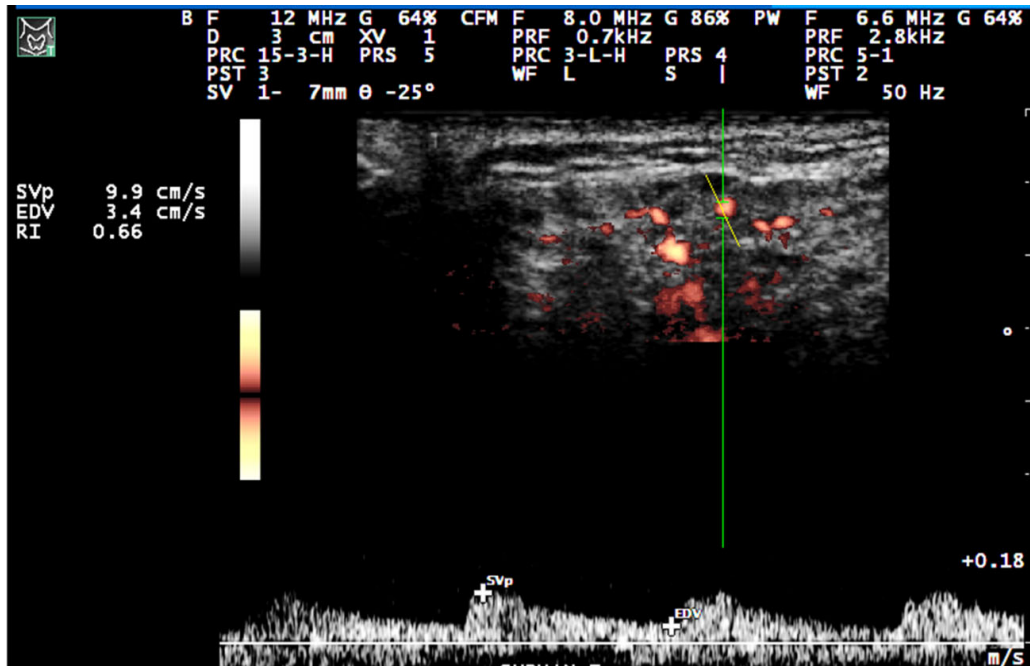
Spectral Doppler image of submandibular gland with grade 4 echo textural damage. Patient with xerostomia, scintigraphy with glandular secretion depression and negative minor salivary gland biopsy (MSGb) showing a decreased resistance index (RI) due to the characteristic hemodynamic alteration of glandular inflammatory activity.
